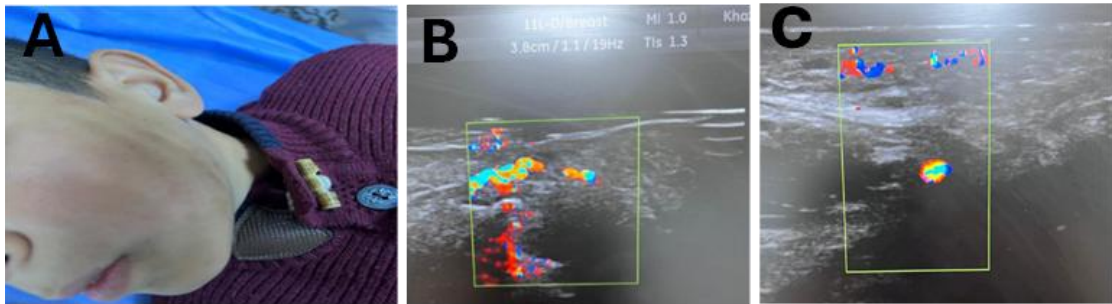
(14 Y) boy undergo Bleomycin injection (A) Cheek swelling (B) color Doppler before treatment (C) color Doppler after one session of treatment.
